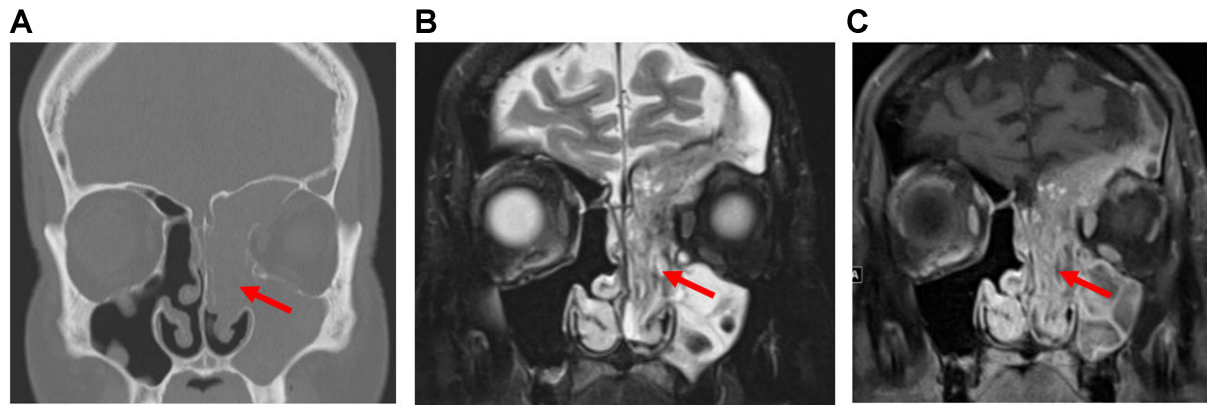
Sinonasal papilloma. (A) Coronal CT image of the sinonasal region in a patient with IP showing an expansile lesion with soft-tissue attenuation in the left nasal cavity, maxillary sinus, frontal sinus, and ethmoid sinus (arrow). Bony remodeling and dehiscence of the nasal cavity and sinus walls, as well as erosion of the ethmoid septa, are also evident; (B and C) Coronal T2-weighted and post-contrast T1-weighted MRI images of the same patient demonstrate CCP, visible as alternating curvilinear hypointense and hyperintense signals diffusely within the tumor (arrows). CT: Computed tomography; IP: inverted papilloma; MRI: magnetic resonance imaging; CCP: convoluted cerebriform pattern.
